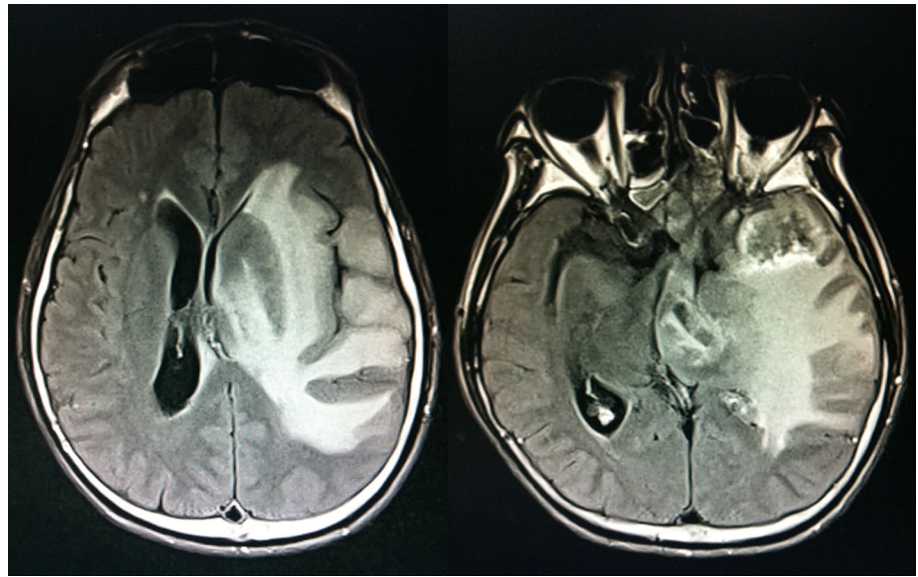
Coronal view of MRI showing extensive enhancing lesion over left temporal lobe
